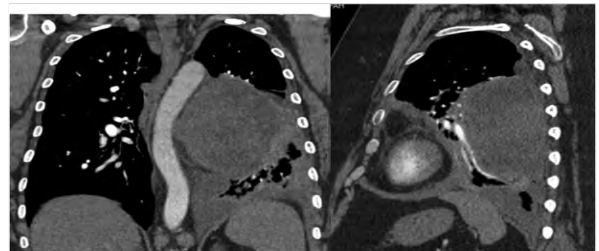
Coronal and sagittal sections of the posterior mediastinal mass, with adjacent atelectasis. CT Angiogram demonstrating mass with deviation of aorta, and vascular supply.
